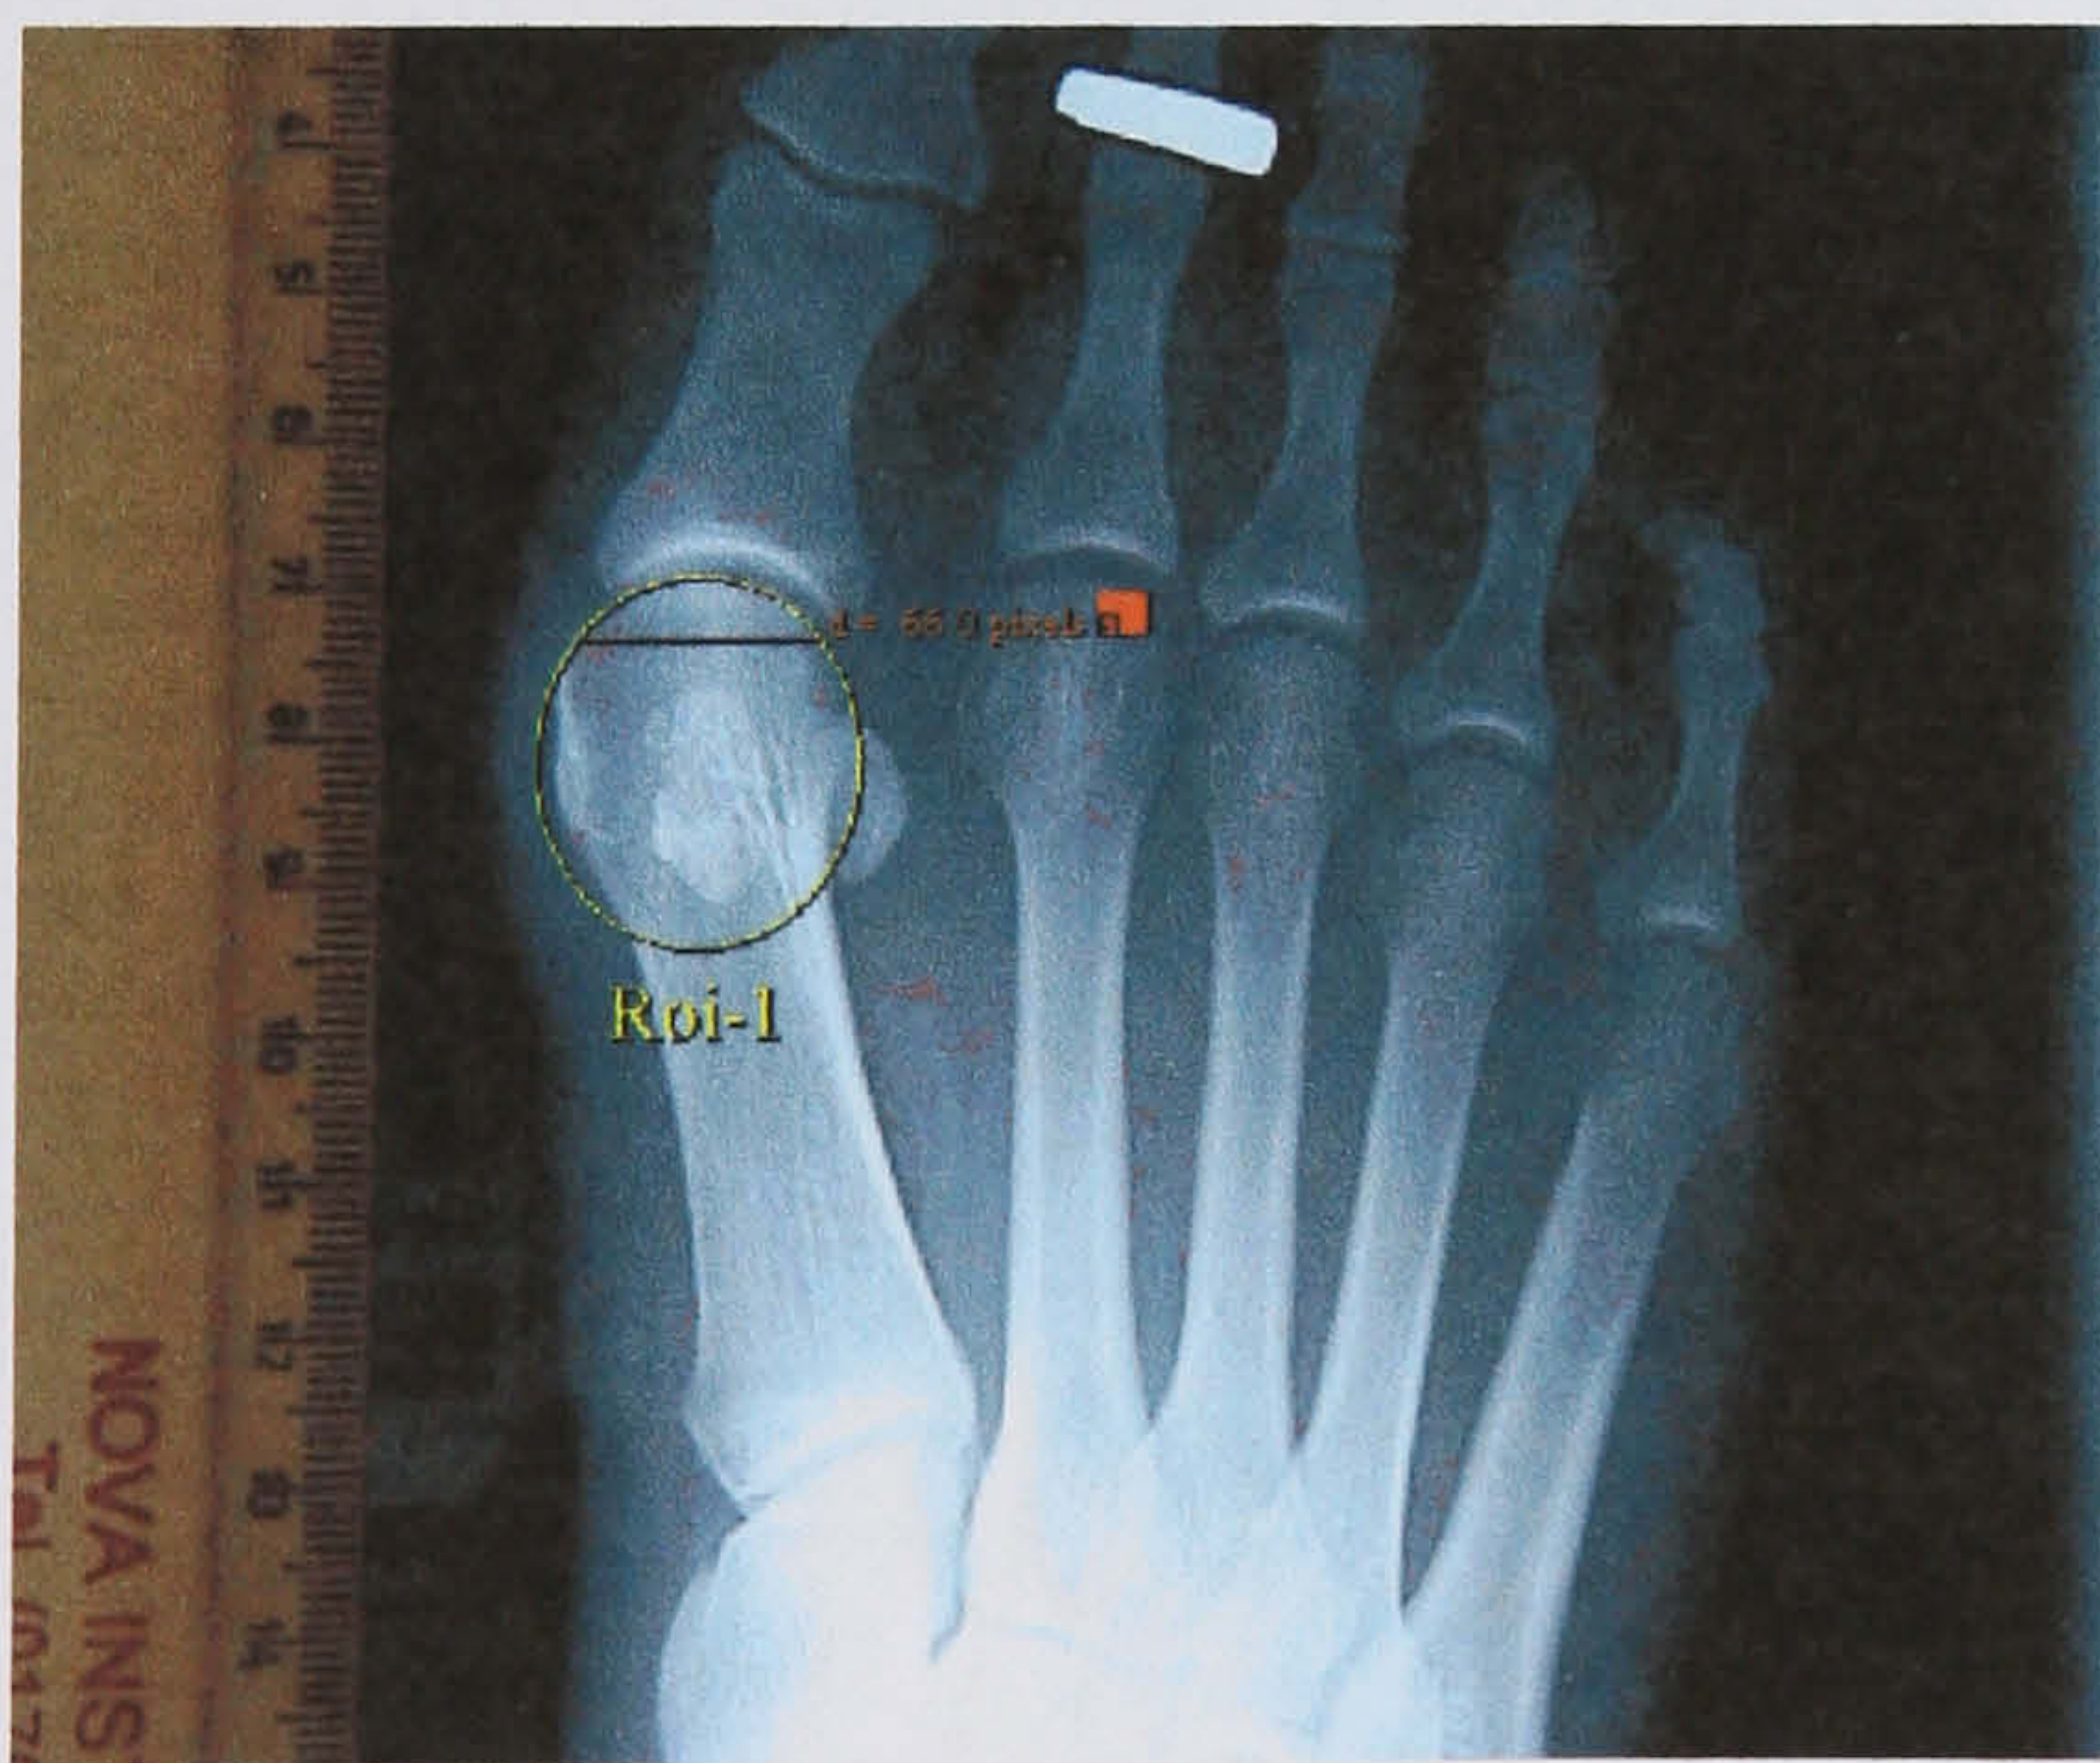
Digitised image of radiograph with chord length and best-fit curve applied.
